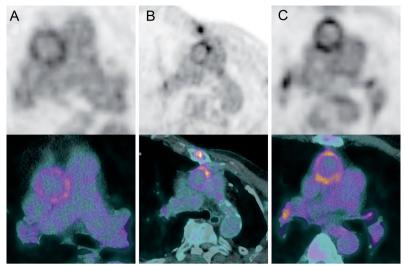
Examples of ¹⁸F-FDG uptake patterns (A: diffuse homogeneous, B: focal, C:diffuse heterogeneous) around the cranial anastomosis. Scaling was set the same for all images and represents SUV with a range of 0-7.
